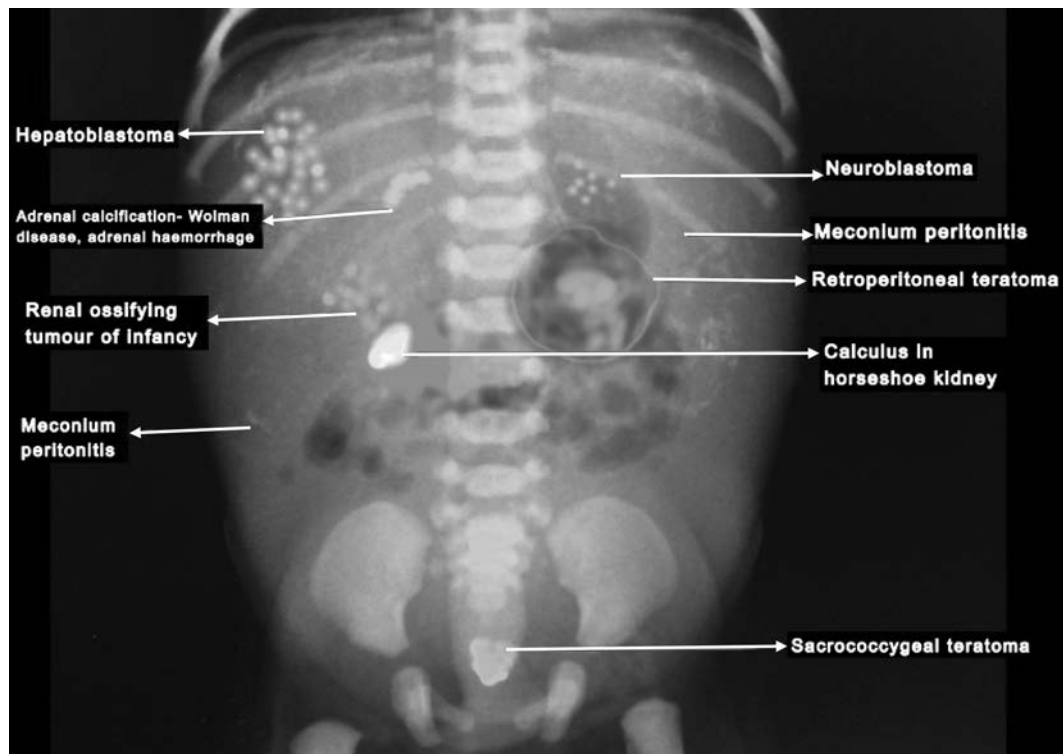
Approach to calcifications in pediatric abdomen radiograph
